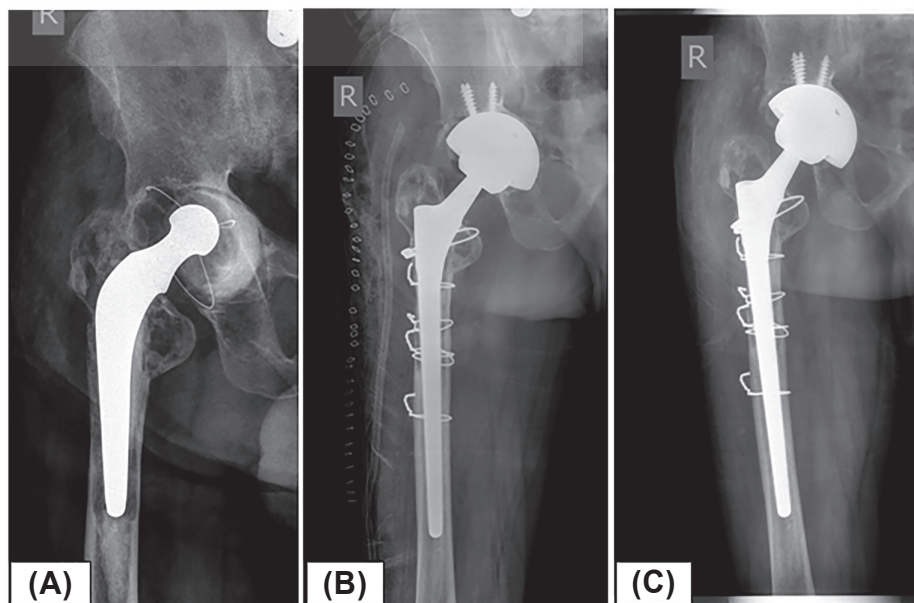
(A) X-ray showing aseptic loosening of the acetabular component and impingement of the femur with the stable cemented femoral component. (B) Immediate post-operative X-ray showing a well-reconstructed extended trochanteric osteotomy (ETO) with cable and metallic wires. (C) Antero posterior X-rays of same patient at the 6-months follow-up showing solid union of the ETO.
